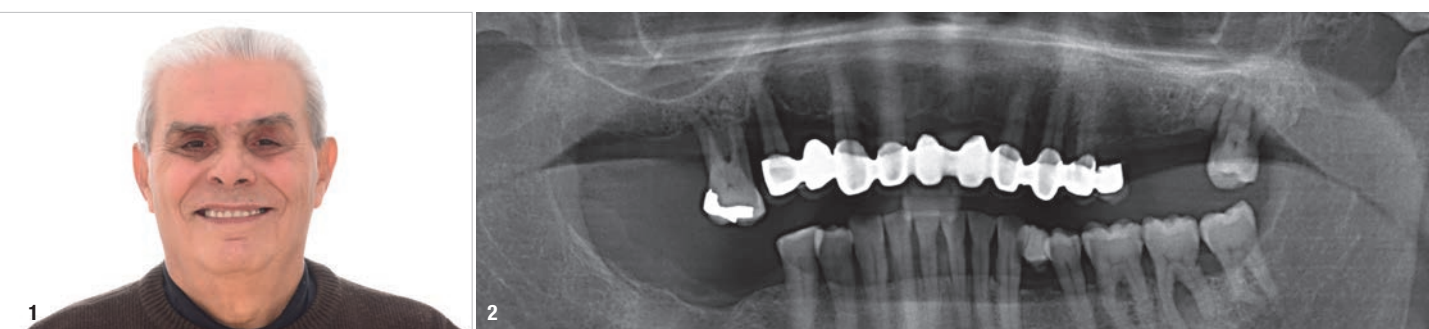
Pre-op situation. Fig. 2: Pre-op panoramic radiograph.
